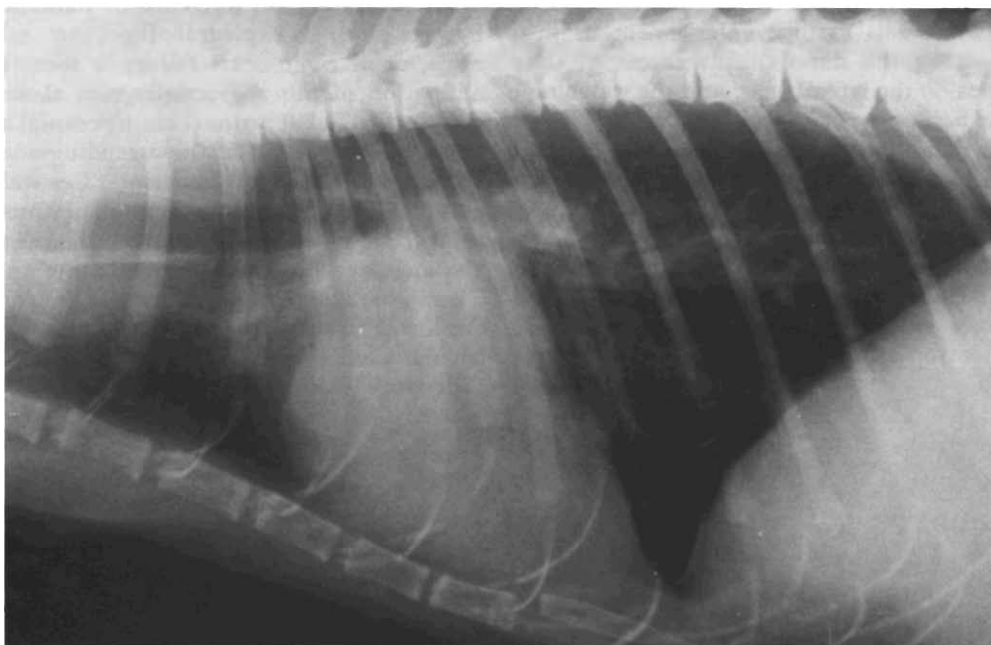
Lateral thoracic radiograph.
